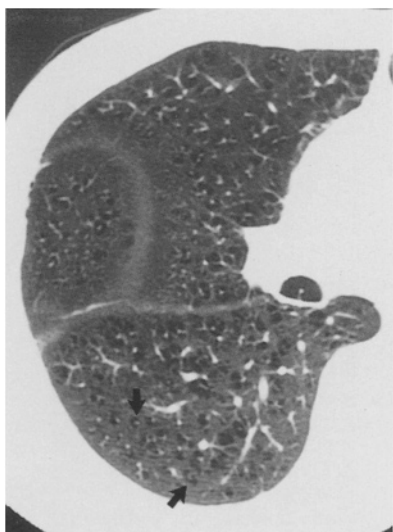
HRCT scan of focal emphysema. Centrilobular areas of low attenuation with a central dot are seen (*arrows*)
